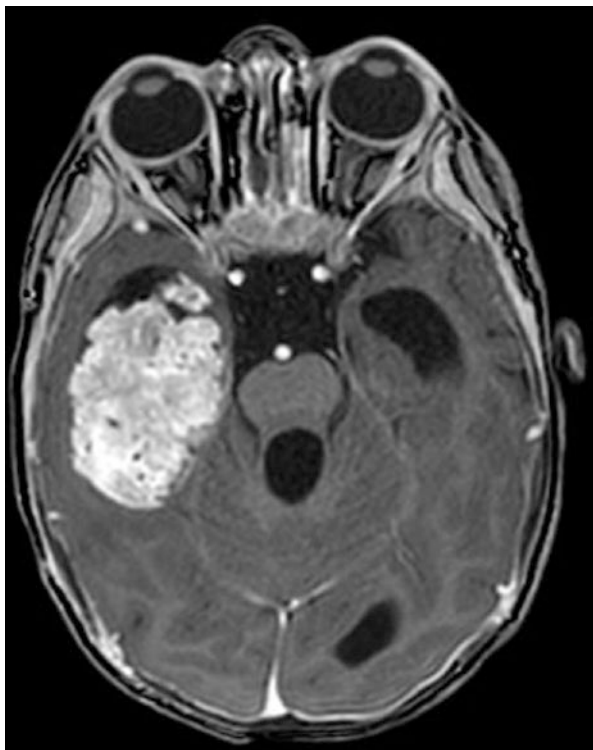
Axial T2-weighted (*left*) and T1-weighted post-contrast (*right*) MRI in a child with a CPC. The tumor is located in the left lateral ventricle, showing less homogenous enhancement and multiple cysts. There is substantial edema in the adjacent temporal parenchyma
